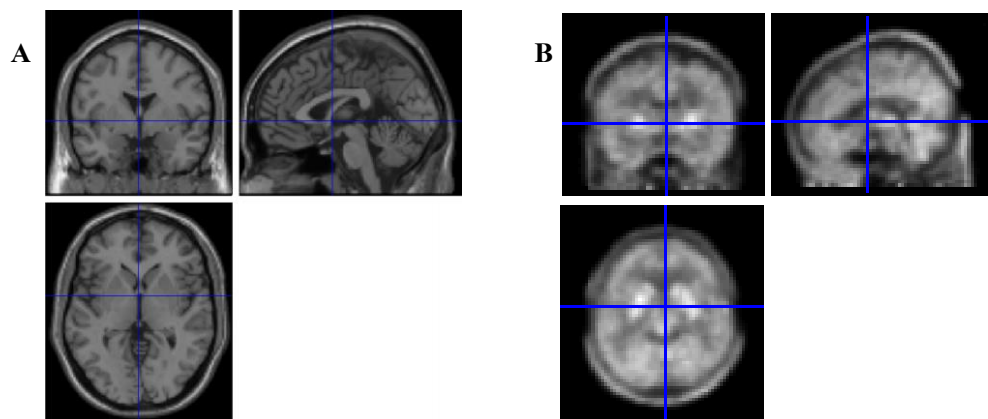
(A) MRI referenced image, and (B) PET reoriented images.
